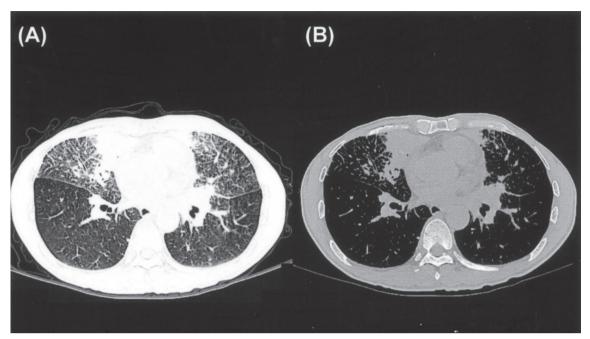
High-resolution computed tomography of the patient's chest. (A) lung window and (B) mediastinum window. These revealed patchy areas of air-space consolidating lesions in the right middle and left lingual lobes of the lungs, diffuse thickening of bronchovascular bundles, intralobular and interlobular septa, and centrilobular opacities in both lungs.
